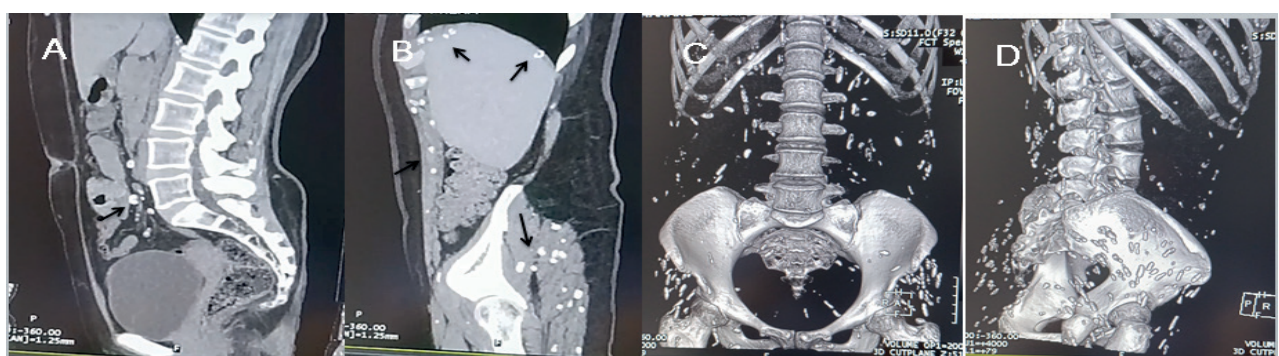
Plain CT of the abdomen. A and B: sagittal reconstructions. C and D: volumetric reconstructions. Small hyperdense images, calcific density in association with calcifications (arrows). A: lymph nodes. B: liver and abdominal and gluteal muscles. C and D: generalized soft tissue calcifications.
